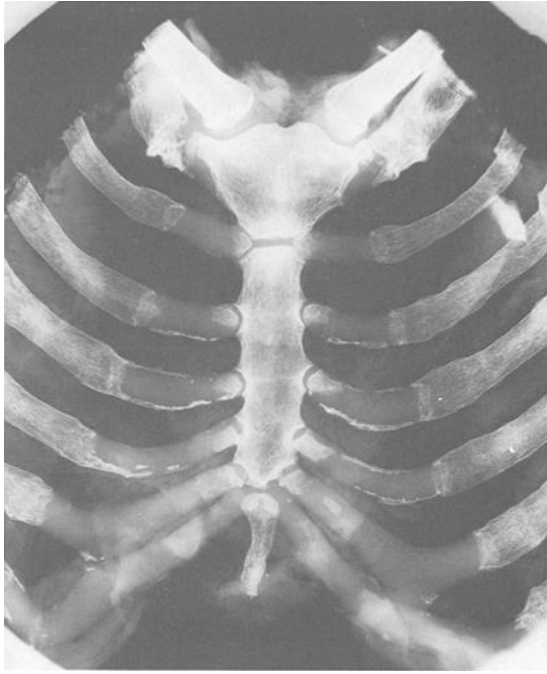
Chest plate X-ray from a 50-year-old man showing relatively heavy peristernal ossification.
